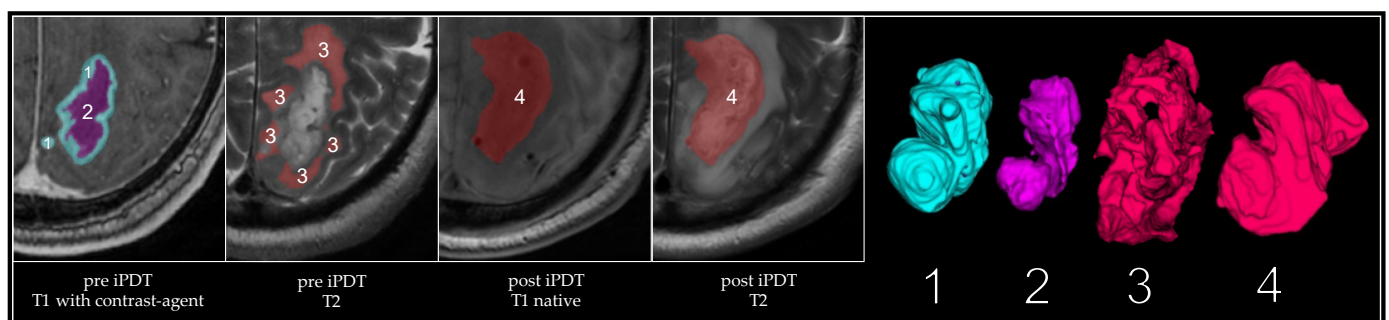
Segmented volumes indicated by color overlays in MR images (T1 and T2 sequences), and separate images indicate 3D volume (1: T1-contrast-enhancing volume) (2: necrotic volume) (1 + 2: tumor volume) (3: edema) (4: iPDT remnant), exemplarily shown for one patient (IPDT 14).
